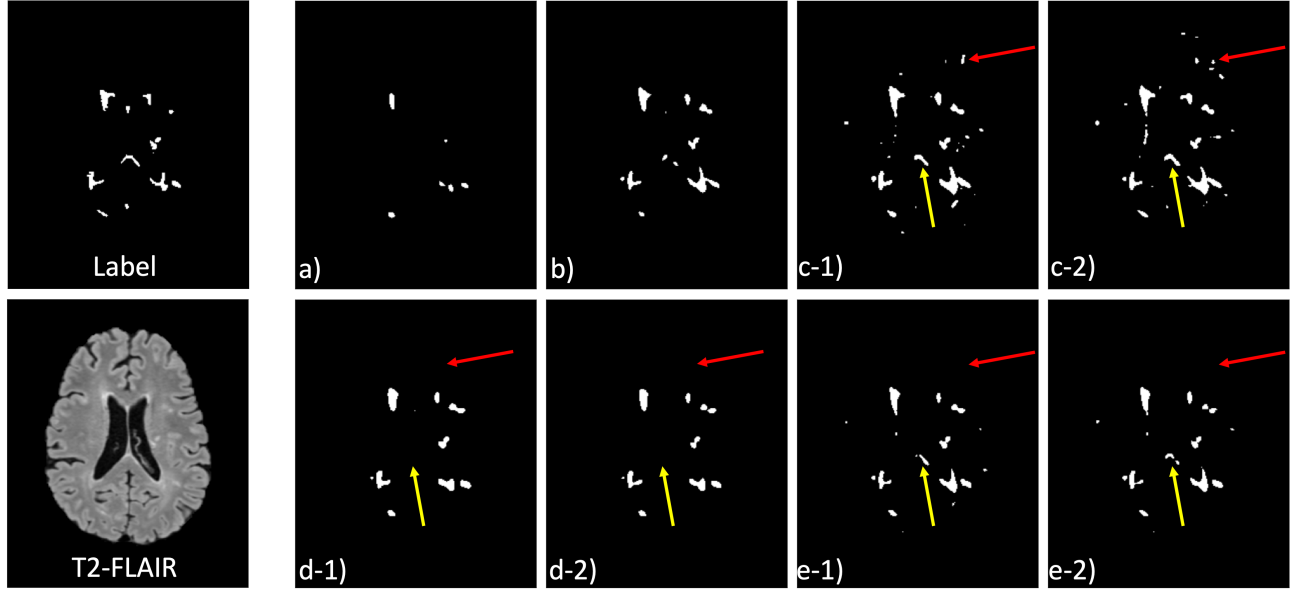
Segmentation predictions with ground-truth label and axial FLAIR slice. (a) Pre-trained prediction. (b) Target site CV. (c) One-shot adaptation after 2 (c-1) and 20 epochs (c-2). (d) Our Zero-Shot adaptation after 2 (d-1) and 20 epochs (d-2). (e) Harmonization-enriched One-Shot adaptation after 2 (e-1) and 20 epochs (e-2). False positive lesions (red arrows) in (c) were avoided in the Zero-Shot (d) and Harmonization-enriched One-Shot (e) strategies. False negative lesions are denoted with the yellow arrows.
